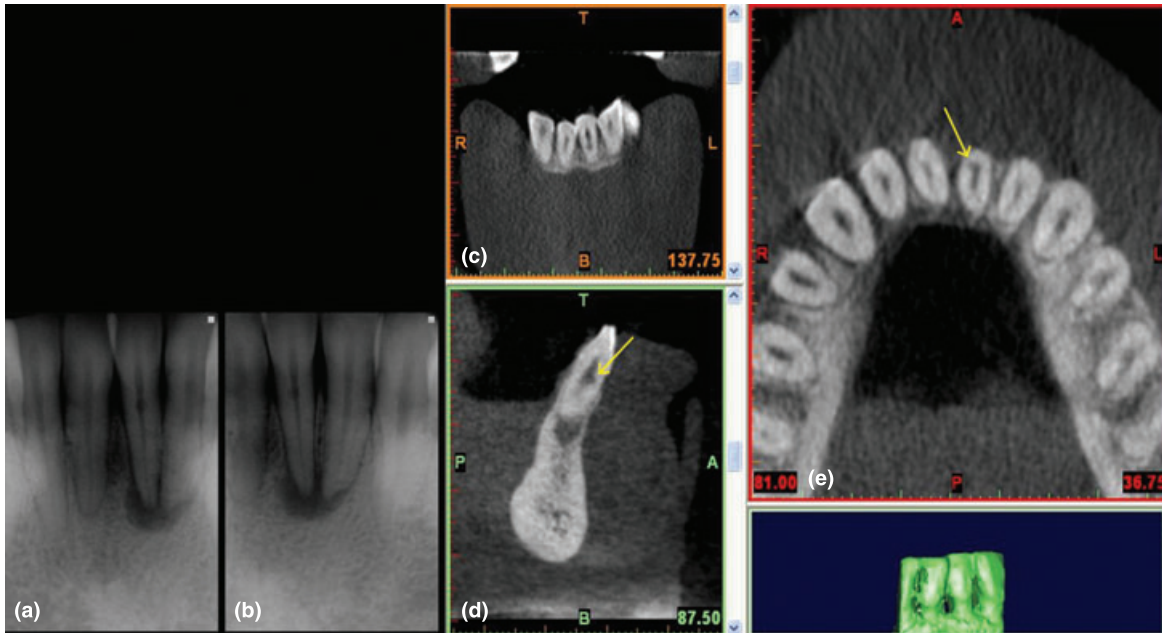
(a–b) Periapical radiographs taken at different views (parallax technique) of the lower left central incisor tooth, note the outline of the root canal is visible through the radiolucent lesion, also the lesion moves in the opposite direction to the X-ray tube in the second radiograph. These signs indicate a diagnosis of external cervical resorption for the radiolucent lesion in the coronal third of the root canal. (c) cone beam computed tomography scans reveal that lesion is actually internal resorption, because of its location on the periphery of the root canal (yellow arrow) it can be easily be mistaken for external cervical resorption with conventional radiographs.
